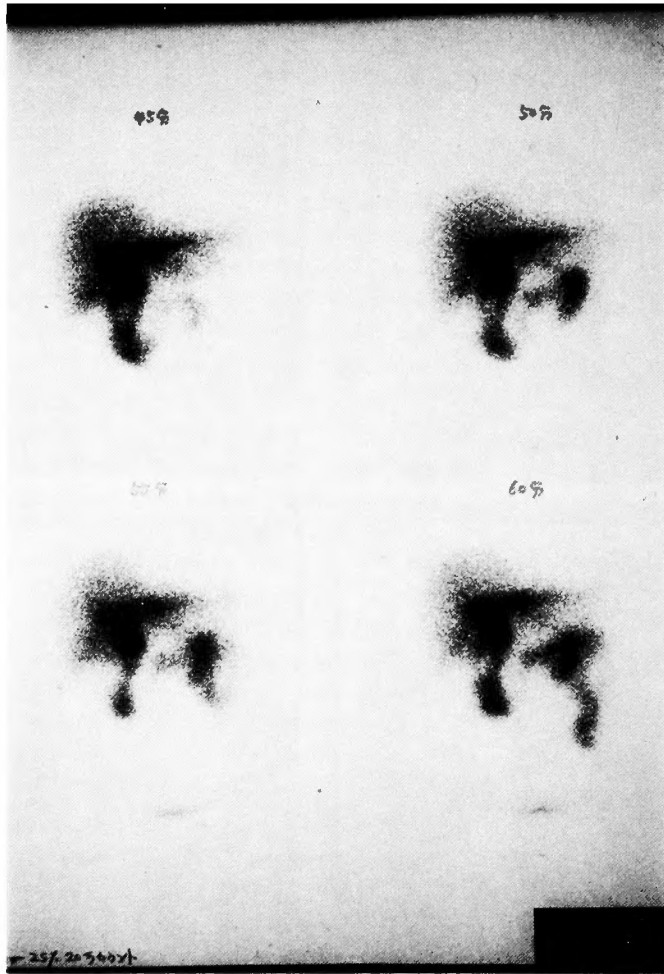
Hepatobiliary scintigram shows the dilatation of choledochus, $^{99m}\text{TcPI}$ was excreted to intestine within 60 min.
